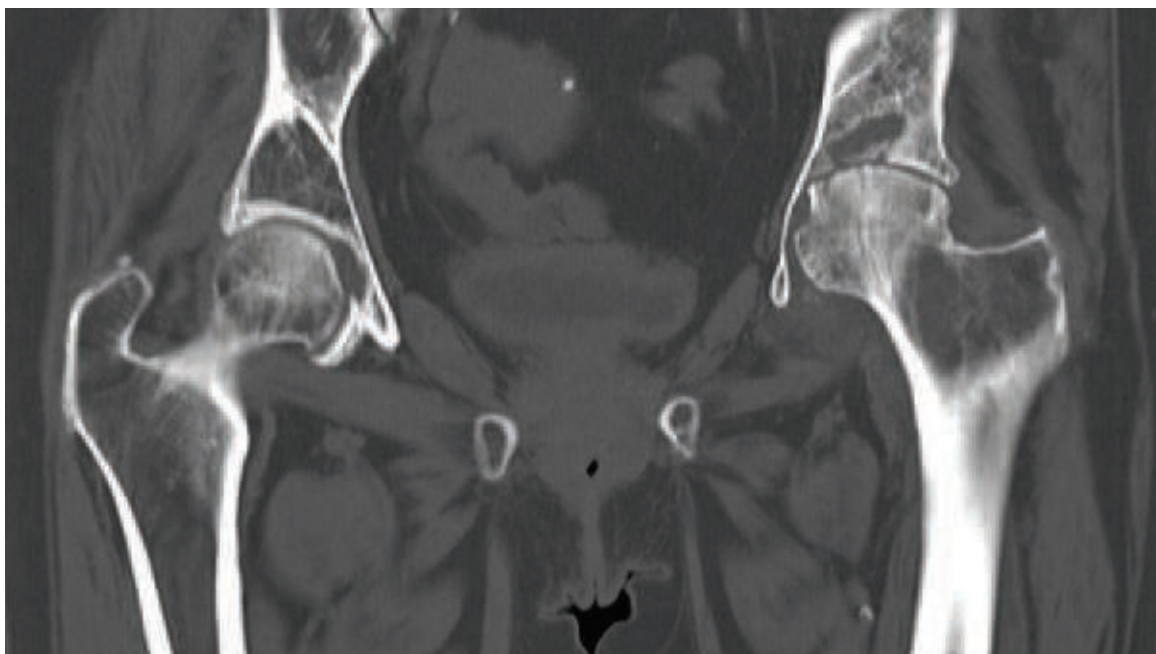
Magnetic resonance imaging shows AVN and collapse of left hip and arthritis in right hip.
